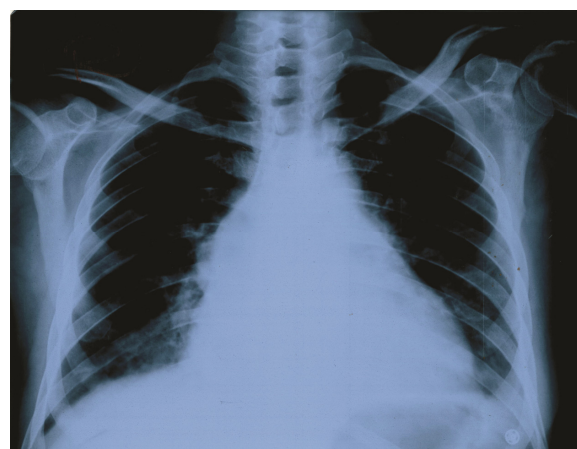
Chest radiograph show mediastinal widening
